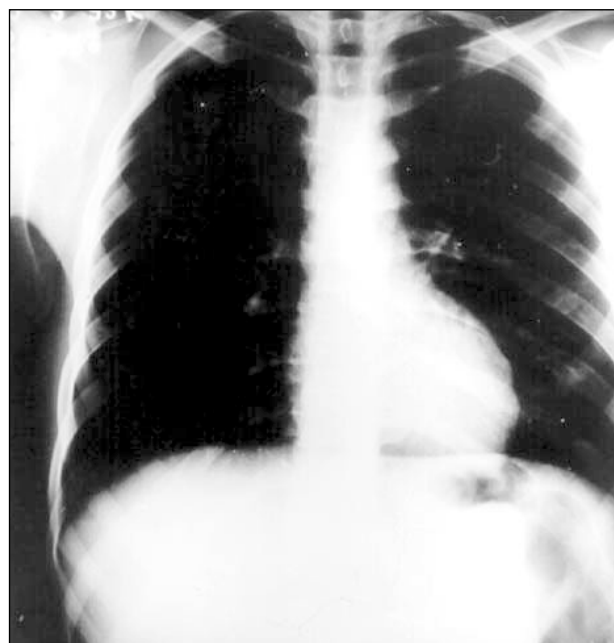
Chest radiography (PA) performed on patient's hospital discharge.
